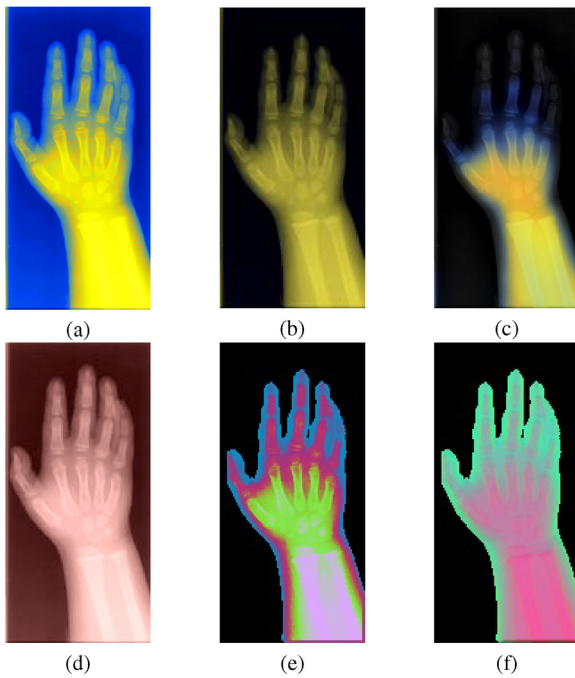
Color perception of CT images. (a) TCGI [3], (b) CTCCS [5], (c) ACGCDT [6], (d) ICTED [7], (e) CPMI-DPHC(LE), (f) CPMI-DPHC(MDS). (For interpretation of the references to color in this figure legend, the reader is referred to the web version of this article.)
